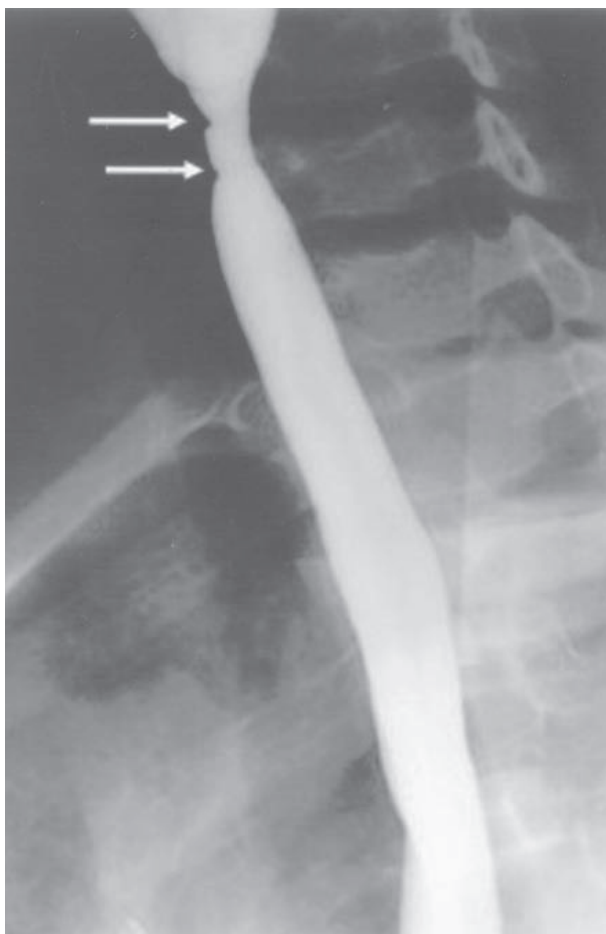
Radiographic study showed the indentations (arrows) of the proximal esophagus indicating webs (oblique view).
